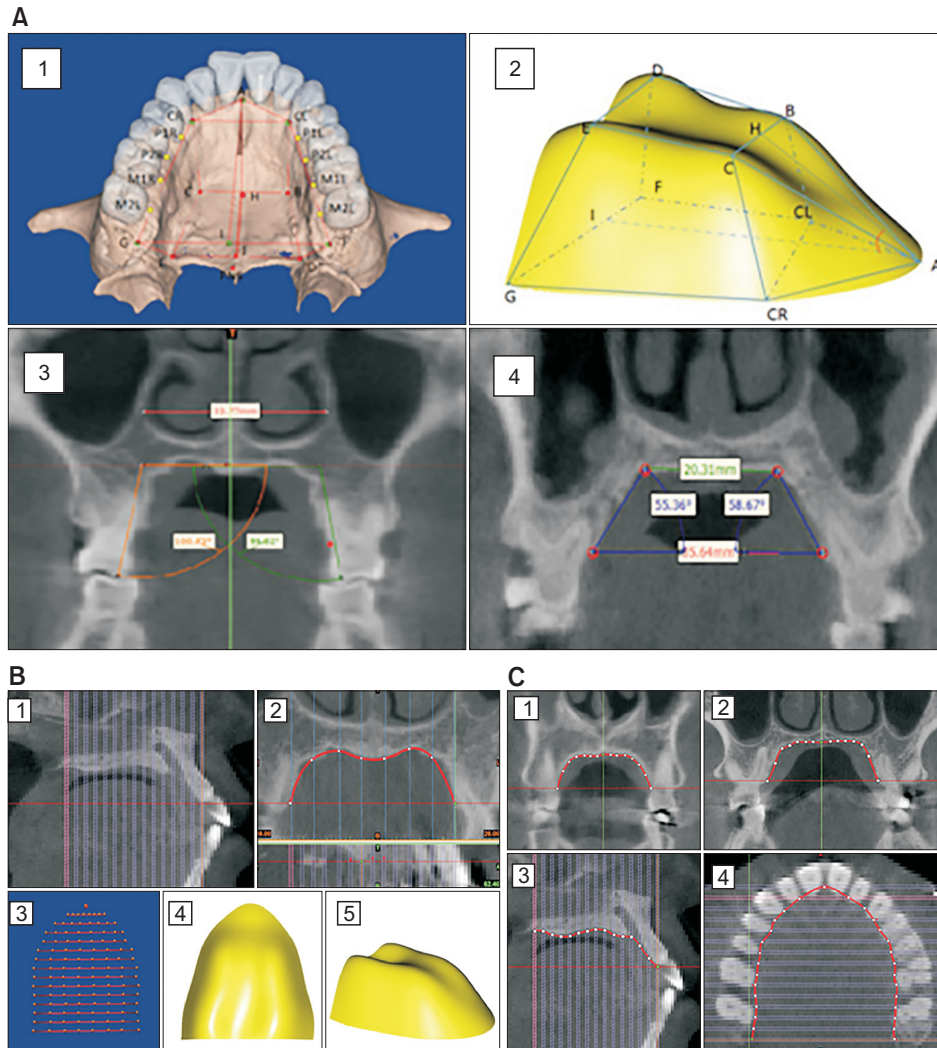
A, Linear and angular measurement for hard palate morphology and the first molar. 1 and 2, Measurement of palatal length, width, and height; 3, the width of the nasal cavity and the angle of the first molar palatal root on the first molar coronal plane; 4, the palatal slope inclination and the width of the palate roof (upper width) on the first premolar and first molar coronal plane. B, The three-dimensional (3D) surface set up using generalized additive models with integrated smoothness estimation based on the cone-beam computed tomography (CBCT) data set. 1, ANS-PNS was divided into 14 pieces in the sagittal section; 2, in each coronal section corresponding to these 14 pieces, along the contour line of the palatal bone, 8 points were chosen; 3, in total, 113 points were chosen for establishing the 3D surface of palatal bone; 4 and 5, 3D surface of palatal bone. C, A nonlinear curve approximation model of the palatal bone contour line in the first premolar (1), first molar (2), palatal suture (3), and palatal undersurface section (4) were set up based on the CBCT data set.
